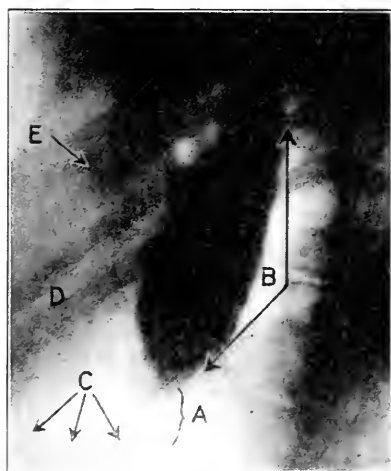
Lateral roentgenogram, showing retention of bismuth meal in a case of ring cancer involving the lower one-sixth of the esophagus, with complete stenosis. *A*, zone of cancerous involvement; *B*, dilated esophagus, proximal to cancer; *C*, diaphragm line; *D*, heart shadow; *E*, aortic arch. The lower portion of the esophagus has a contour resembling normal, and plate might readily be mistaken for one of "cardiospasm" if care is not exercised in locating the cardiac end of the esophagus in relation to the position of the diaphragm line and the gas shadow in the stomach. (Roentgenogram by Joseph Johnson.)
